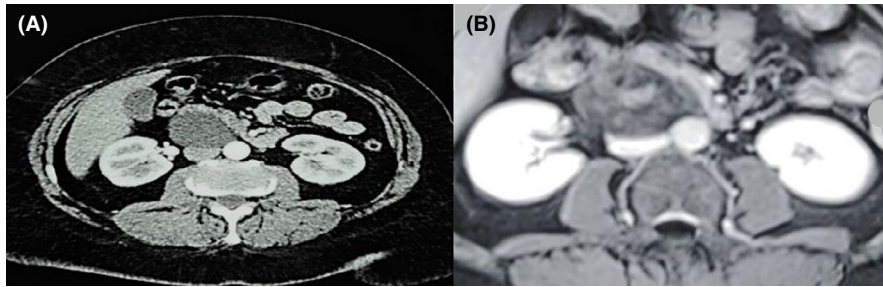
Radiological images of the retroperitoneal tumor. (A) axial view of the abdominal computed tomography scan showing a retroperitoneal cyst-like mass. (B) MRI axial view
